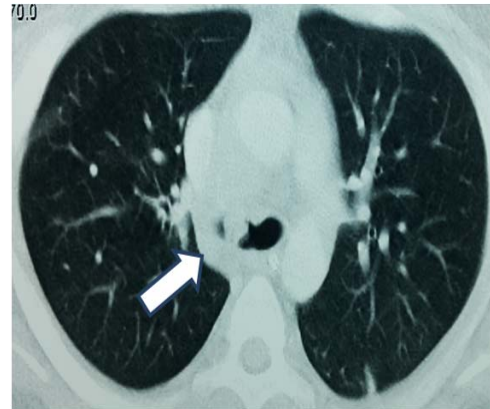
Contrast CT scan of the thorax showing an enhancing mass arising from the lumen of the right main bronchus
